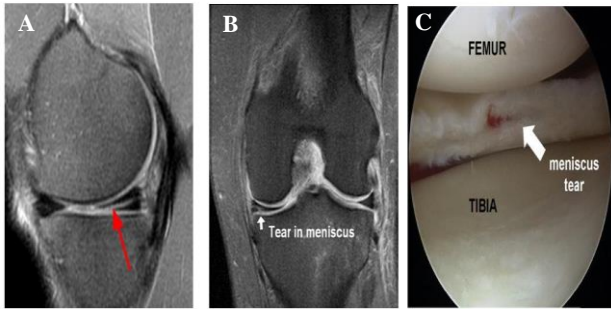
Images showing MRI sagittal view; A) coronal view, B) of meniscal tear, C) Arthroscopic image of meniscal tear.
